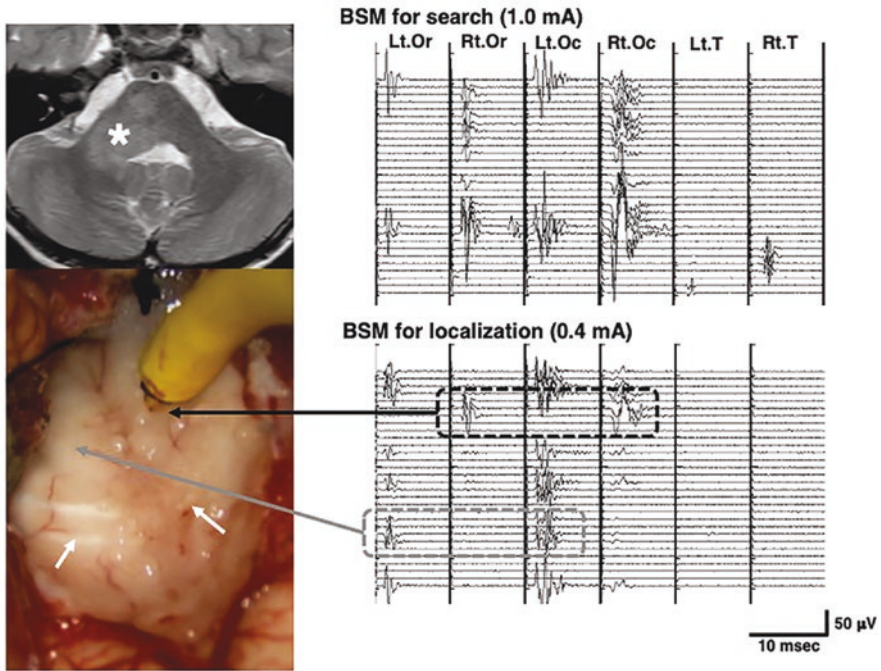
A 7-year-old girl with a tumor extending from the cerebellar peduncle to the brainstem. The girl presented with ataxic gait, which gradually worsened over a few years. Hoarseness and occasional swallowing difficulty developed slowly. Upper left: An MRI revealed a high signal intensity from the right cerebellar peduncle to the brainstem on T2-weighted image (asterisk), and there was no enhancement after the gadolinium injection. Upper right: BSM for search of the CNMNs with the stimulation intensity of 1.0 mA. Lower: With the use of a stimulation intensity of 0.4 mA, precise localization of the CNMN VII was performed. The black arrow indicates the right CNMN VII, and the gray arrow is the left one (white arrows: stria medullaris)
